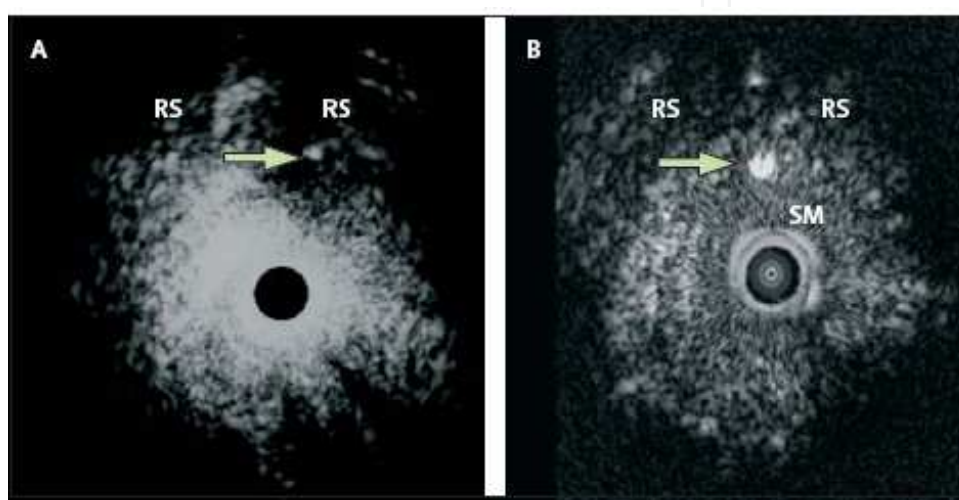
Cross-sectional ultrasonography images of the urethra and the rhabdosphincter (A) The tip of the needle (marked with an arrow) is positioned at the inner aspect of the rhabdosphincter (RS) for injection of myoblasts. (B) The tip of the needle is placed at the outer aspect of the submucosa (SM) for injection of fibroblasts (Strasser et al, 2007b).
